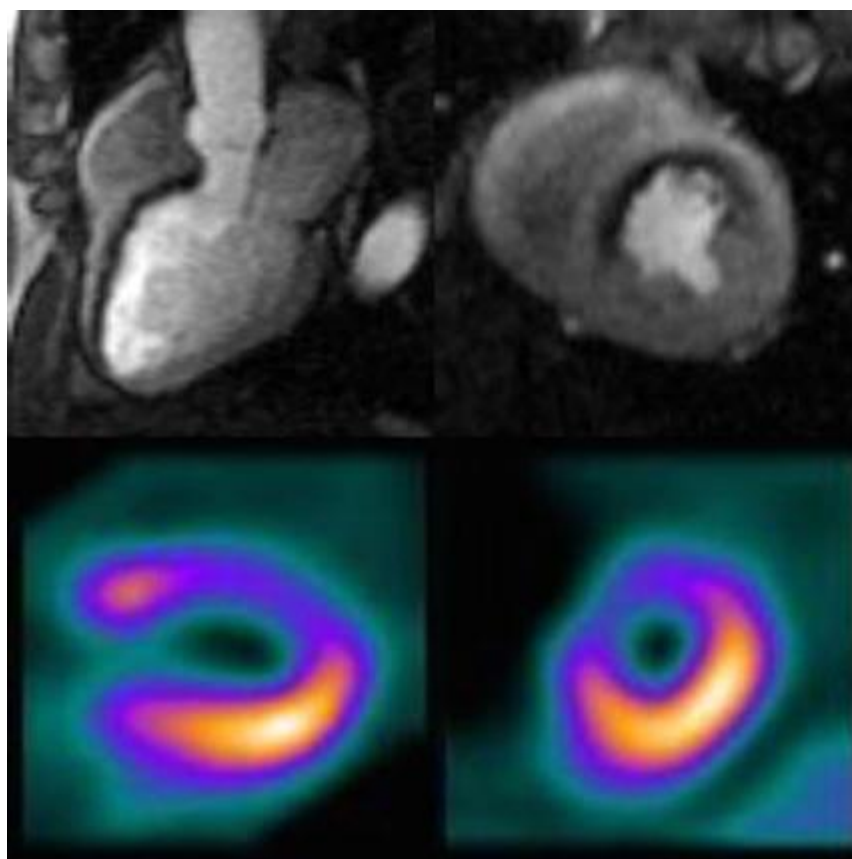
MRI vs SPECT perfusion images
